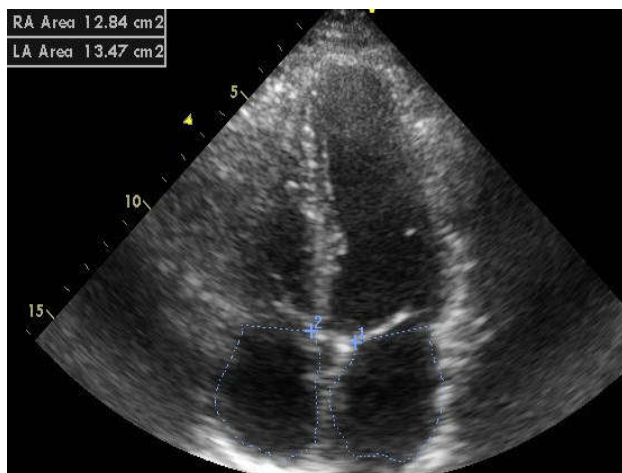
Measure of Right Atrium(Apical 4 chamber view)
